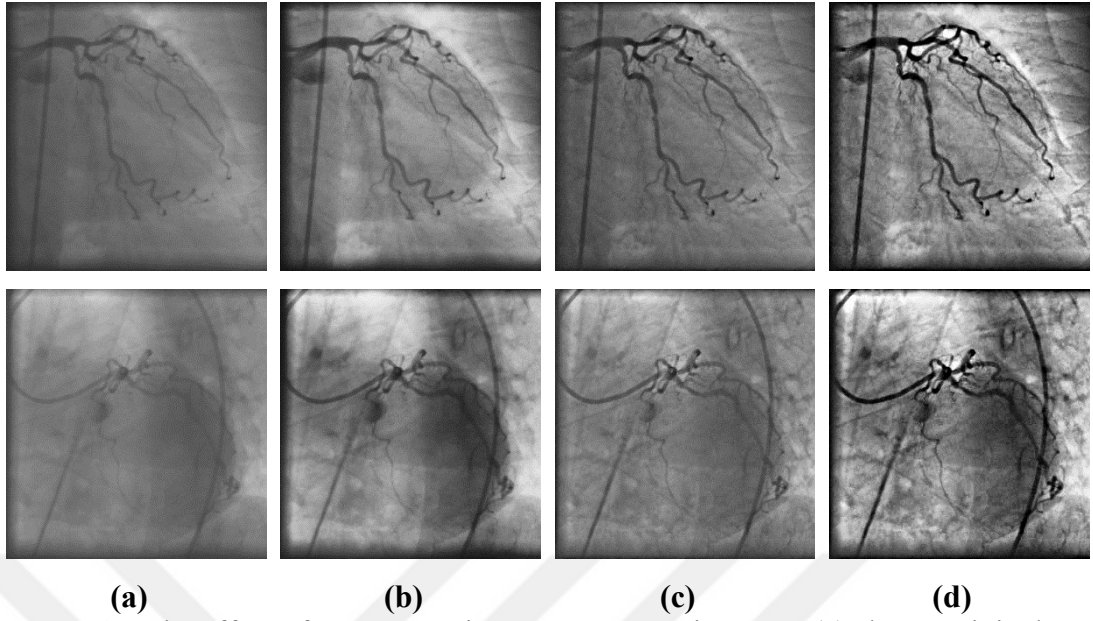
The effect of pre-processing on X-Ray angiograms. (a) shows original X-Ray image, (b) and (c) show CLAHE and MTHT pre-processed images of (a). (d) is MTHT followed by CLAHE.
